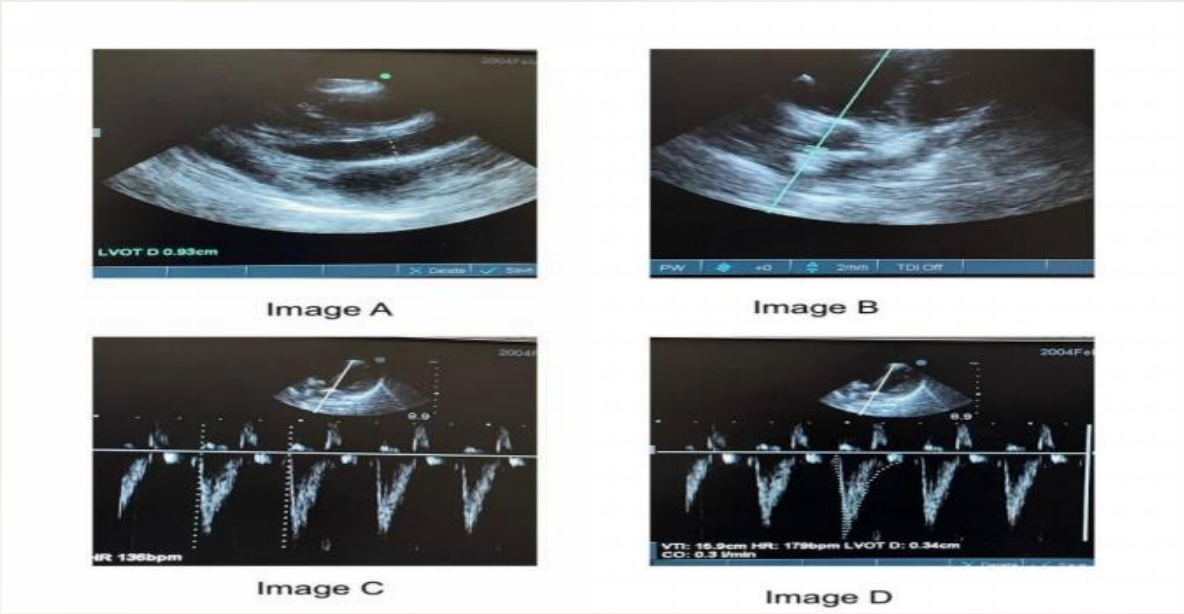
Cardiac output (COP) measurement by Echocardiography (CI=COP/BMI)
